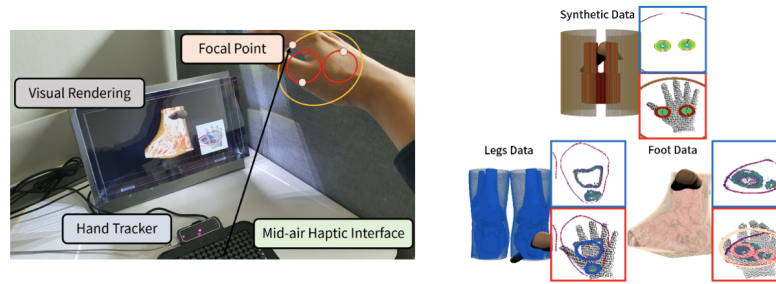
Left: Experimental setup showing the user interacting with a 3D hologram of a CT scan. First, the user defines a region of interest, then a haptic rendering algorithm produces a set of tactile patterns which represent the internal structures of the region selected that can be explored and felt in real time by the user. Right: The volumetric data is converted into a tactile periphery render and is displayed to the user’s hand. Reproduced from [75].
